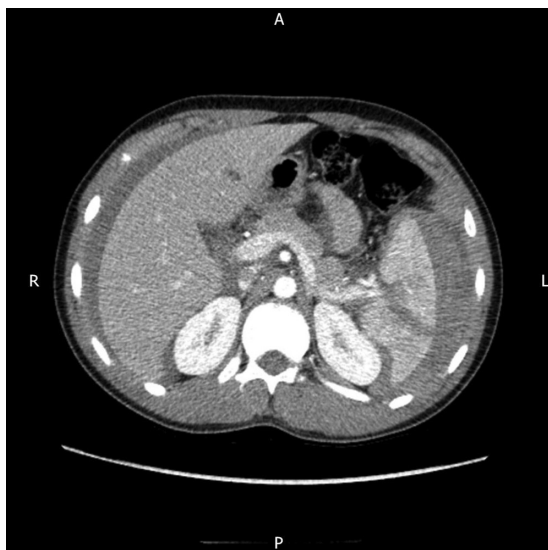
CT in blunt abdominal trauma showing splenic rupture with a large amount of free fluid in the peritoneal cavity.
